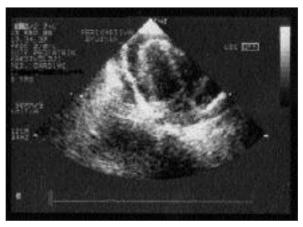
Pericardial effusion and cardiac tamponade in transthoracic echocardiography.
